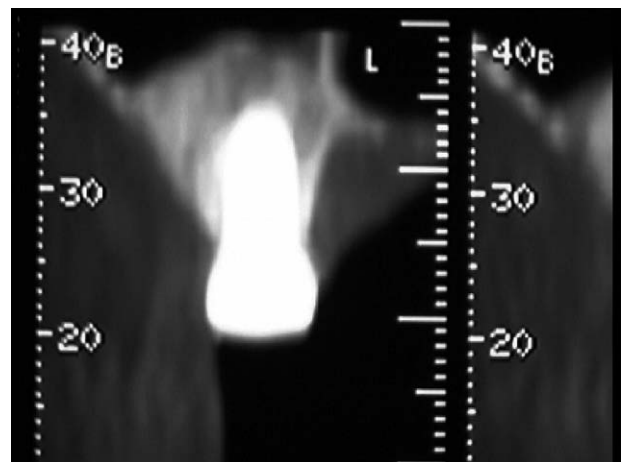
Postoperative CT scan of the same patient with good bone healing at 3 months.
